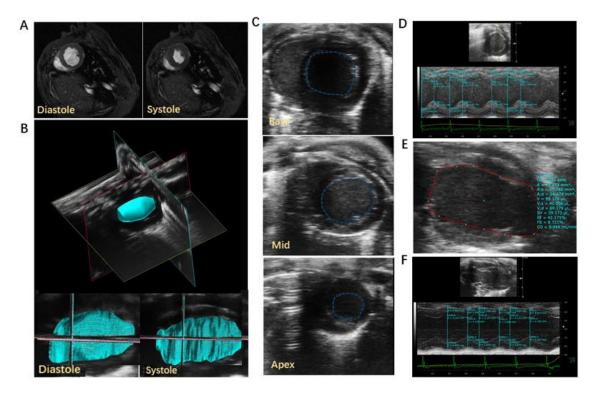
Representative images using cardiac MRI, 4D-US, and traditional ultrasound techniques. A: Mid-ventricular MRI images of an infarct heart during end-diastole (left) and end-systole (right). B: 4D-US images of an infarcted heart (top) and tracing of 4D-US reconstruction during end-diastole (left) and end-systole (right). C: Simpson's multiplane mode from base (top) to apex (bottom). D: SAX M-mode. E: PSLAX B-mode. F: PSLAX M-mode. MRI, magnetic resonance imaging; 4D-US, 4-dimensional ultrasound; SAX M-mode, 1-dimensional motion-mode in short axis; PSLAX B-mode, 2-dimensional brightness mode in single-plane parasternal long-axis view; PSLAX M-mode, 1-dimensional motion-mode in long axis.
